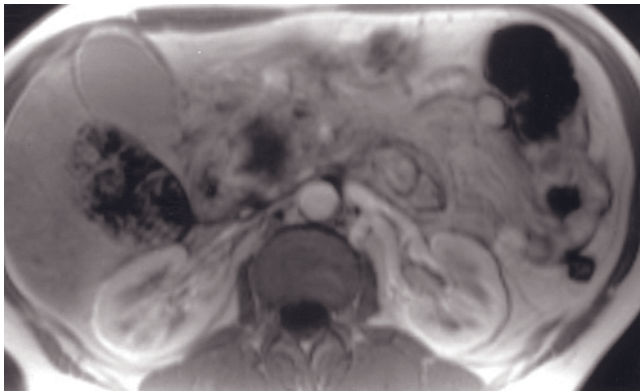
Diffuse pancreatic adenocarcinoma. T2-weighted echo-train spin-echo (*a*), T1-weighted SGE (*b*), T1-weighted fat-suppressed SGE (*c*), immediate postgadolinium T1-weighted SGE (*d*), and 90-s postgadolinium fat-suppressed SGE (*e*, *f*) images. The pancreas is diffusely enlarged and hypointense on T2 (*a*) and T1 (*b*)-weighted images, with diminished and heterogeneous enhancement on early (*d*) and late (*e*) gadolinium-enhanced images. The tumor encases the superior mesenteric artery (arrow, *d*) and occludes the superior mesenteric vein and splenic vein. Extensive infarction of the spleen (*f*) reflects the vascular occlusion of splenic vessels.
